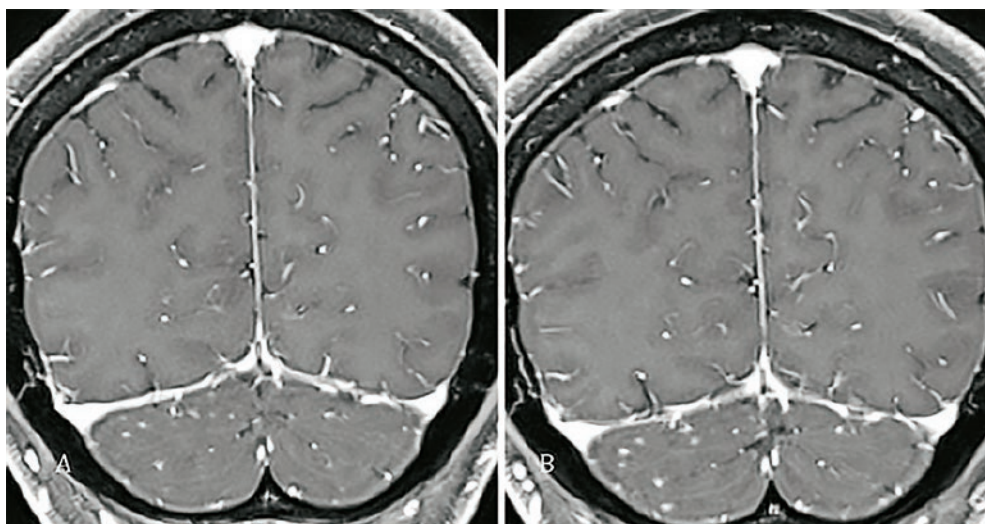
MRI, coronal contrast-enhanced brain images, show nodular leptomeningeal enhancement in the posterior fossa in the HIV patient with cryptococcus meningitis.
